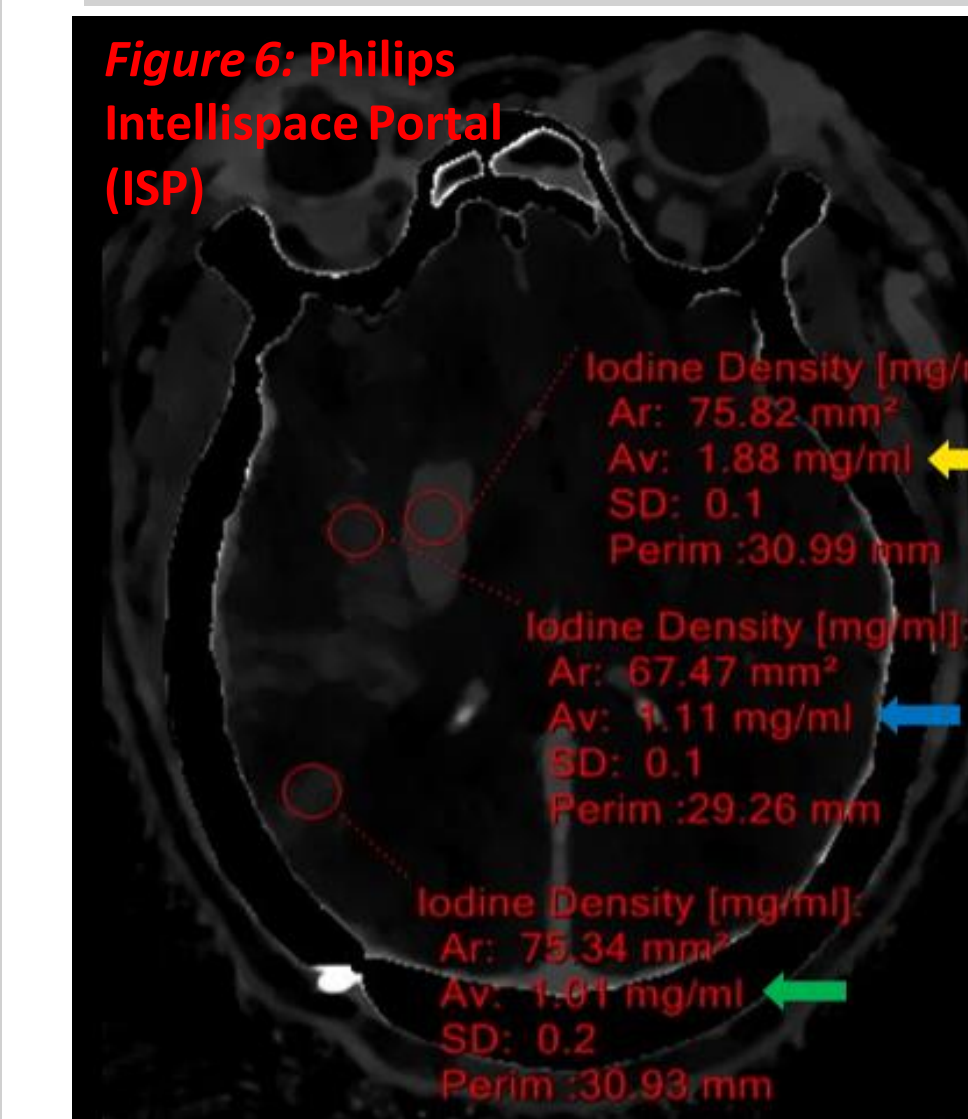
Philips IntelliSpace Portal (ISP) software demonstrating quantification of ID in individual ASPECTS locations, Ex. lentiform (1.88 mg/mL, yellow), insula (1.11 mg/mL, blue), & M3 (1.01 mg/mL, green). In a univariate analysis, ASPECTS insular, M1, M5, & M6 ID were associated with MCE, though max ID was not.
